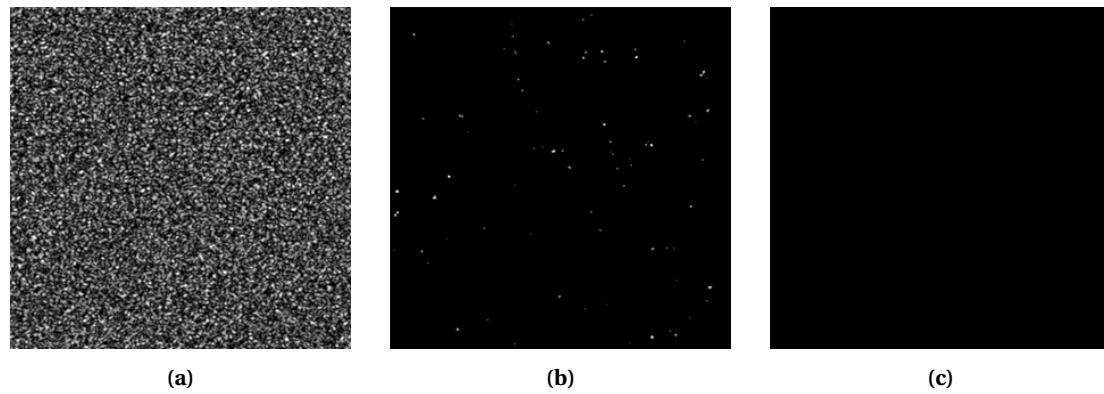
Improvements to CNN prediction resistance to noise and noisy images. a) Original MR image, b) early version of the trained CNN with many false positive predictions, and c) final version of the CNN, which is nearly fully noise-resistant.
